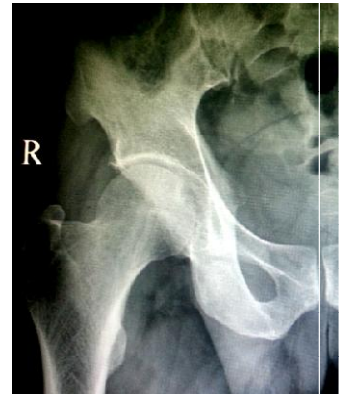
Digital X-ray showing left side fracture neck femur and Singh index grade 3 on right side
